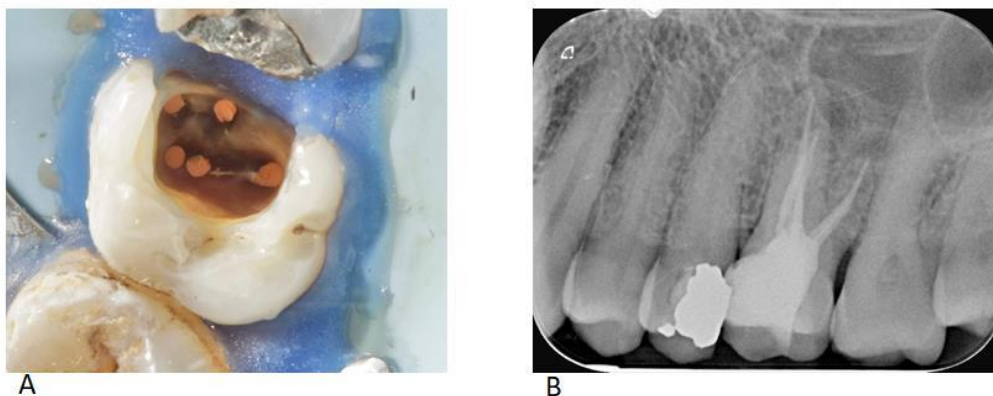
(A) Clinical view after obturation under rubber dam isolation. (B) Immediate post-operative periapical radiograph showing obturation of MB1, MB2, P, and a confluent DB fill after mid-root merger
